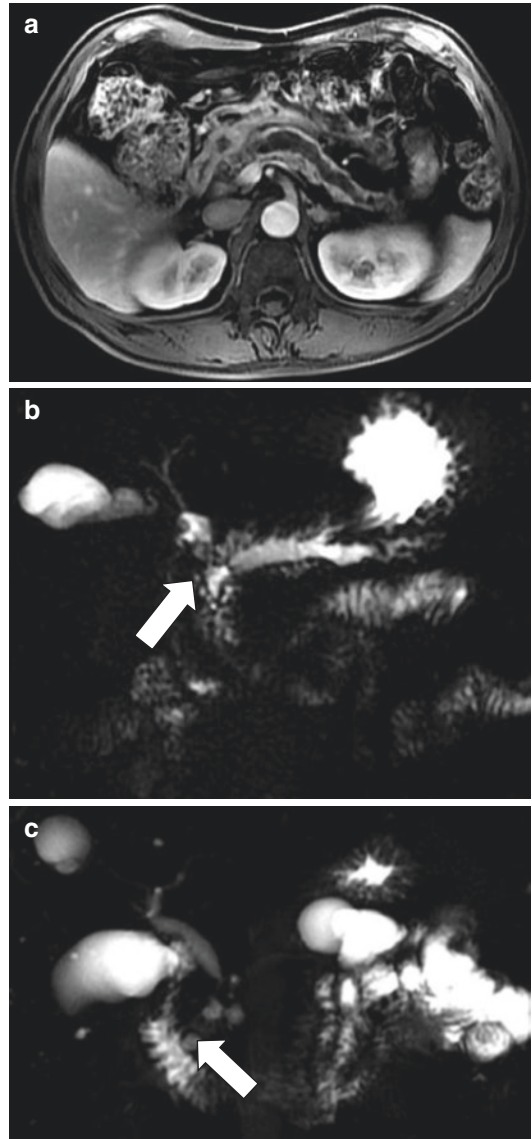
Chronic pancreatitis on MRI. A 52-year-old male with history of recurrent severe epigastric pain. Axial T₁-weighted fat-saturated spoiled gradient echo image (a) and Coronal MRCP (b) demonstrate a dilatation of the main pancreatic duct, side-branch ectasia, and filling defects in the head of the pancreas (arrow). A 45-year-old male with chronic pancreatitis Coronal MRCP (c) shows severe strictures of the main duct with pseudocyst formation in the head (arrow)
